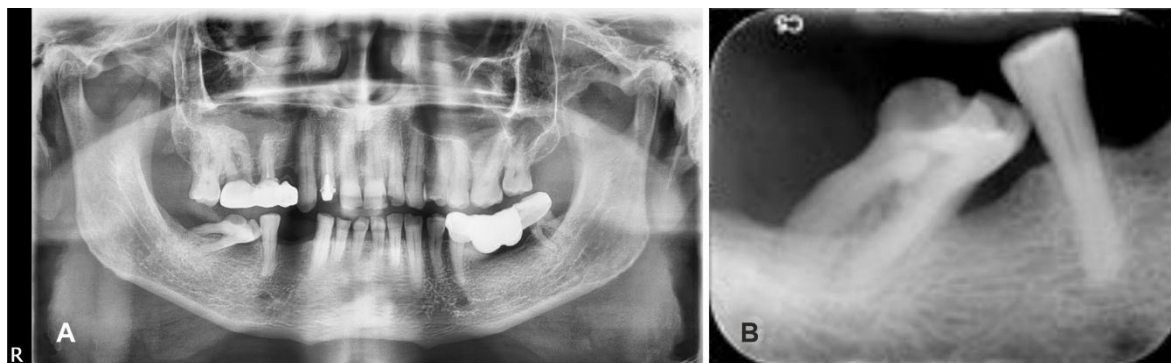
Initial radiological investigation: (A) Panoramic X-ray showing the unusual, overerupted horizontal position of the third right molar, and its mesial contact with the second premolar; (B) Periapical X-ray showing the degree of bone resorption in the distal and mesial areas, and also the presence of alveolar bone between the roots. R: Right.
